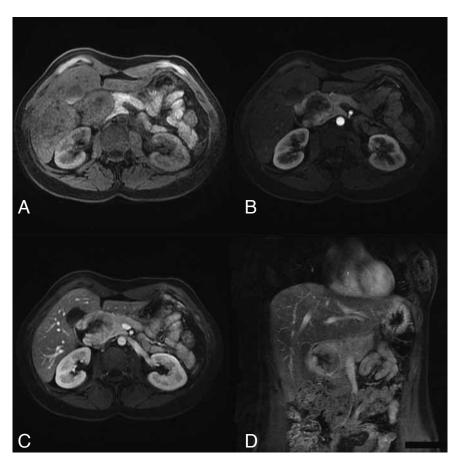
Axial (A) T1-weighted MRI image after contrast shows an isointense mass displacing the pancreatic head. The axial MRI image in arterial phase (B) demonstrates early peripheral enhancement in the pancreatic site of the mass with a central hypointense area. The arrow reveals the normal duodenal external wall. Images C, axial and D, coronal, shows the portal phase with progressive enhancement of the periduodenal well-delineated rounded mass with peripheral enhanced ring.
